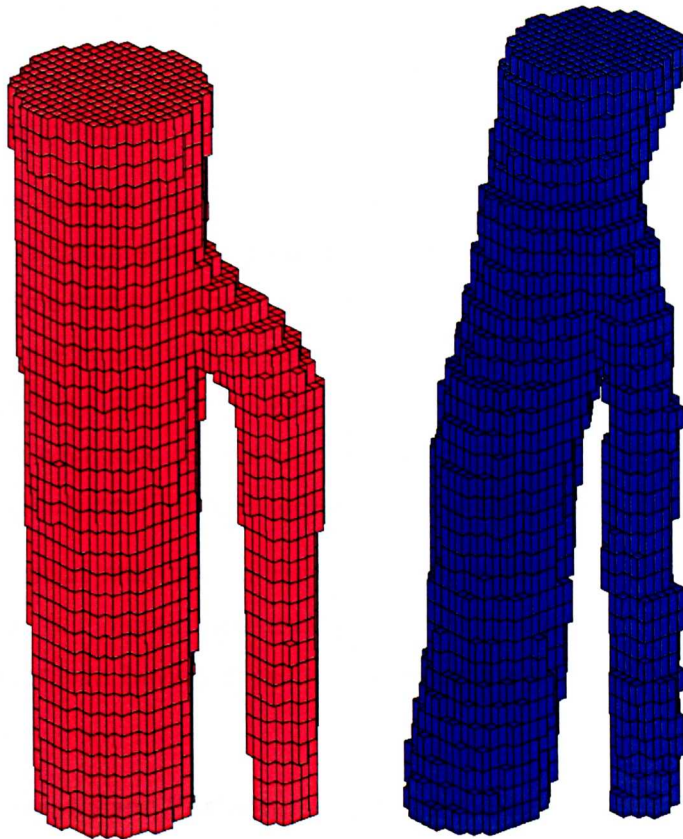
Segmented volume data sets based on initial idealised mesh (red) and segmented MRI (blue).
